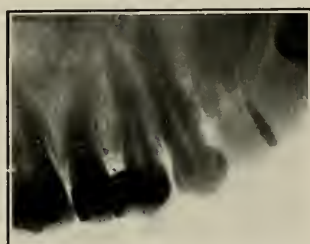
Radiograph by Peabody, of South Orange, N. J.
